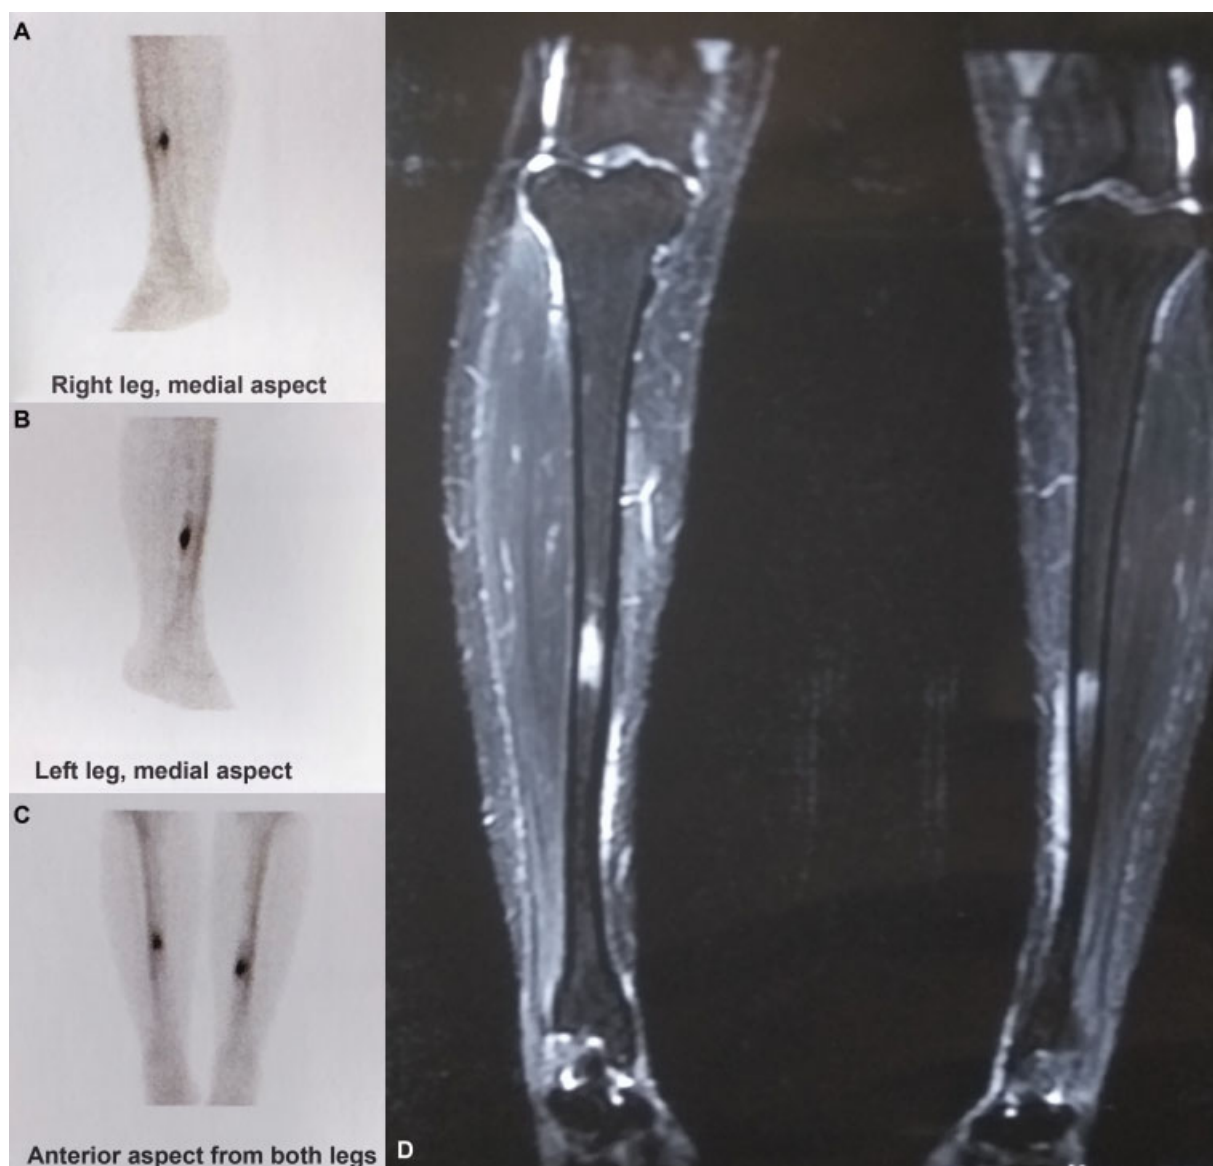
Test images revealing tibial stress fractures. (A, B and C). Bone scintigraphy scan images, (D) T2-weighted magnetic resonance imaging scan.
